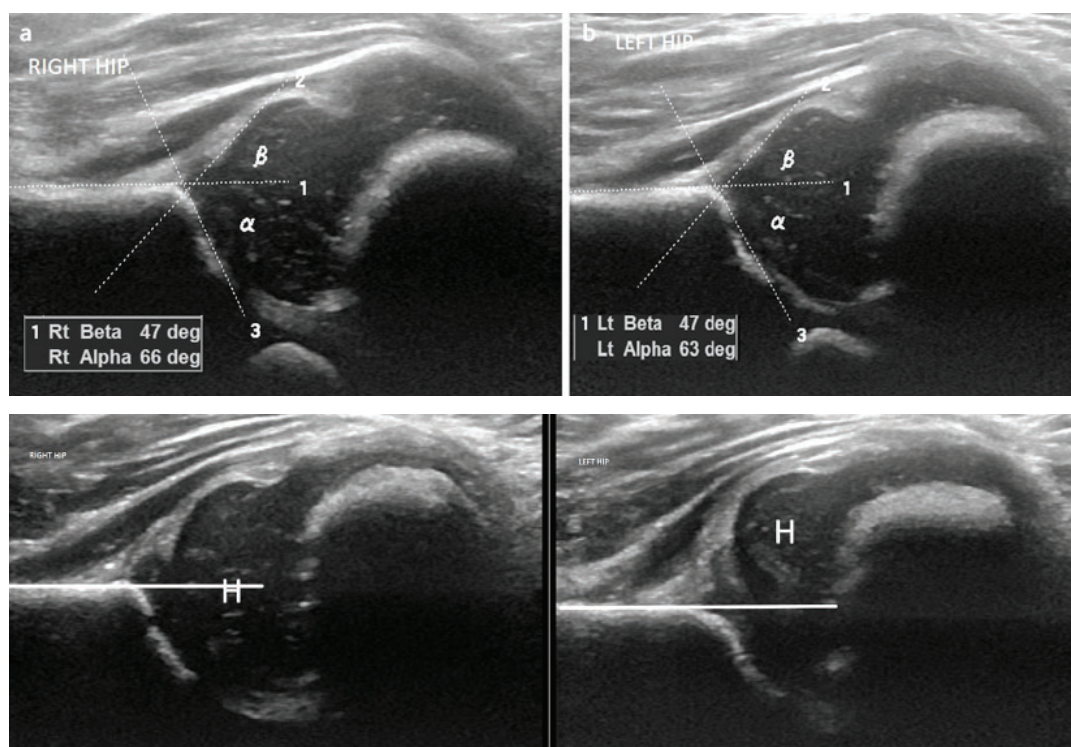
Normal ultrasound of the hips with normal alpha and beta angles as per the Graf technique. The alpha angle is $>60^\circ$ on either side
